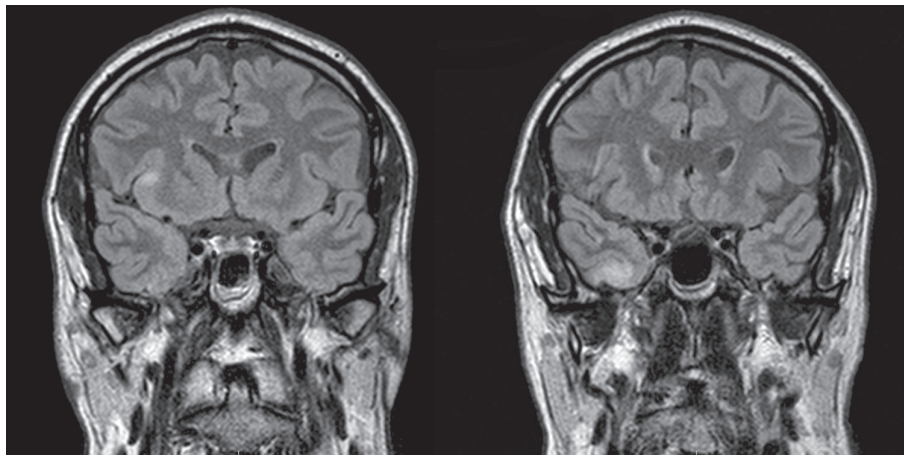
Brain MRI showed an area of T2/ FLAIR hyperintensity of <8 mm in diameter in the right insula and inferior temporal gyrus without gadolinium enhancement.
